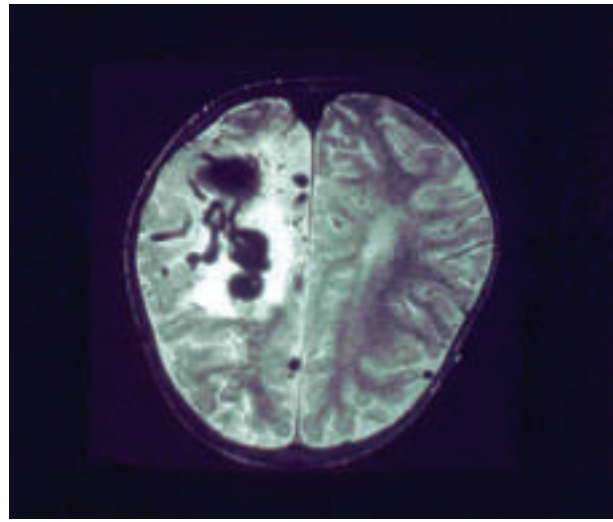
Cerebral AVM by MRI.
